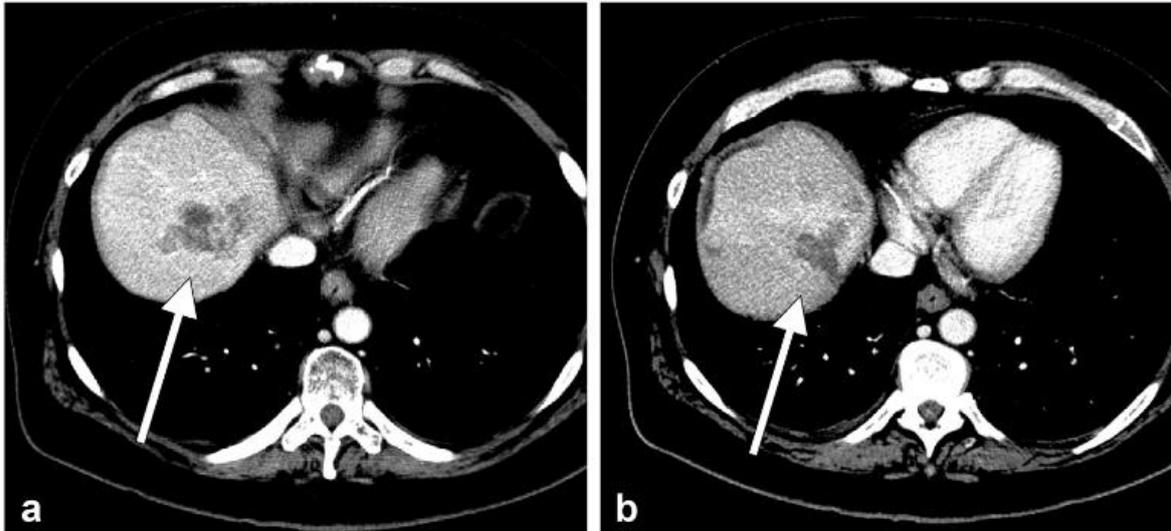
Treatment response after the transarterial radioembolization of a metastasis in the dome involving segments 7 and 8 (patient 6). (a) Pretreatment, contrast-enhanced computed tomography demonstrated heterogeneous enhancement, with central hypodensity. Procedural angiography confirmed isoenhancement/hypoenhancement of the mass relative to the liver parenchyma (not shown because of poor image quality and artifact). (b) Follow-up, contrast-enhanced computed tomography 3 months after transarterial radioembolization demonstrated partial response, despite baseline hypovascularity. Figure from Bibok et al, 2022. [104]
